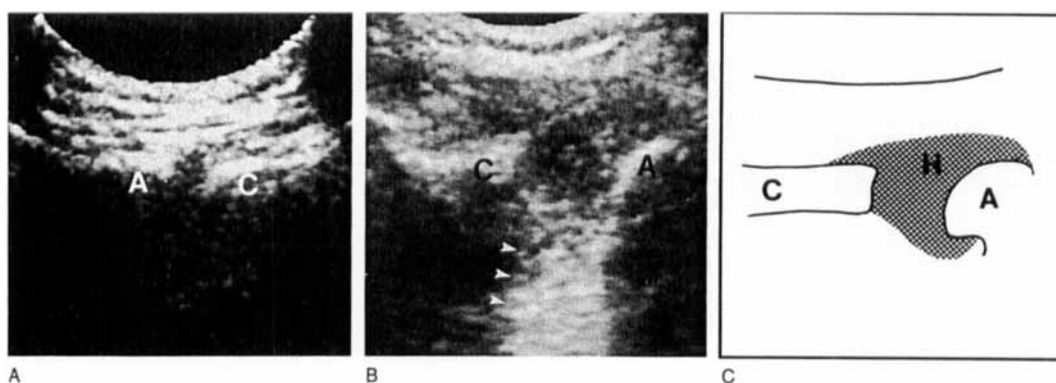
A. Normal acromioclavicular joint space. B and C. Acromioclavicular joint subject to trauma with effusion located in and above the joint (H). Radiographs did not show distension. A = acromion, C = clavicle, small arrows = enhancement.
